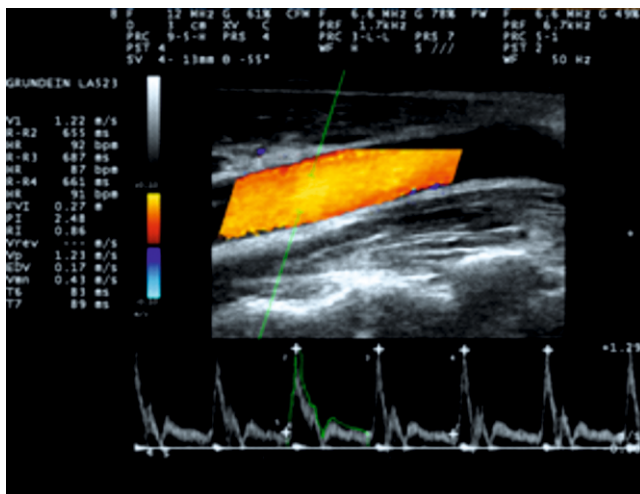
Normal Doppler spectral of left CCA
